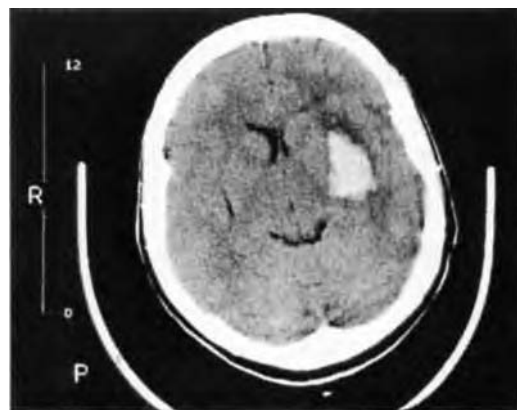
CT scan on admission shows left putamen haemorrhage.
